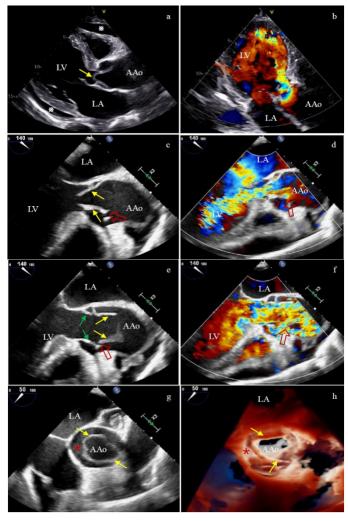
The echocardiography showed views of the Stanford Type A3 aortic dissection with proximal intima intussusception in long axis (a-b: preoperative TTE and c-d: intraoperative TEE during diastole and with color Doppler respectively, e-f: intraoperative TEE during systole) and short axis (g-h: intraoperative TEE during systole). Yellow arrow: intimal intussusception. Green arrow: aortic valve leaflet. Red arrow: site of intimal tear. *: hydropericardium. *: false lumen. LA: left atrium; LV: left ventricle; AAo: ascending aorta.
